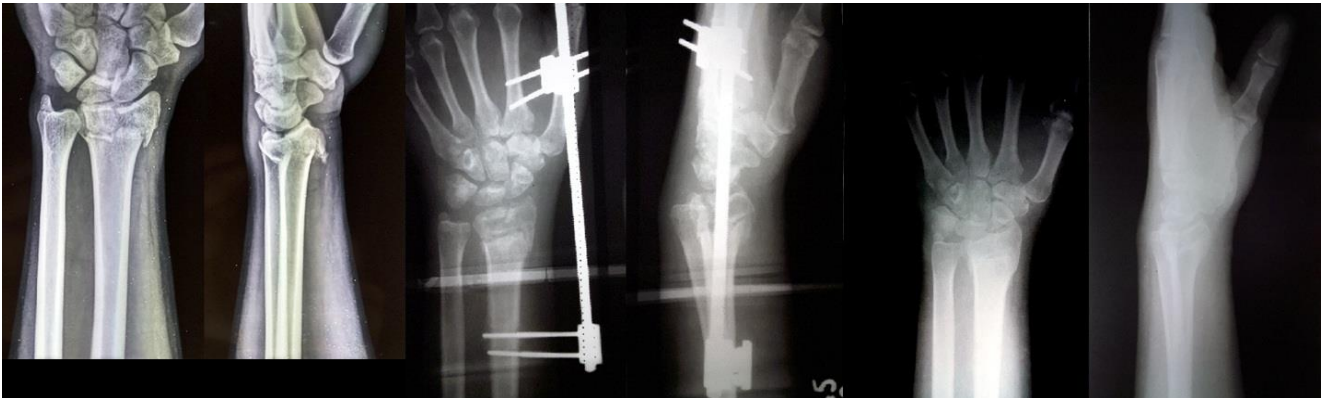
Pre OP, immediate post OP and 6 months post OP X-rays-external fixation.
